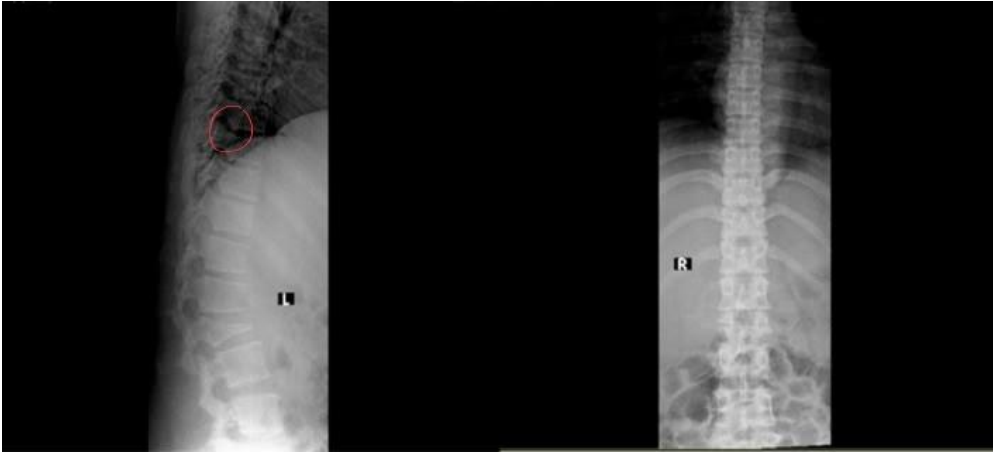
Thoracic spine radiograph (AP/lateral views) demonstrating vertebral compression deformity and straightened thoracic alignment.
